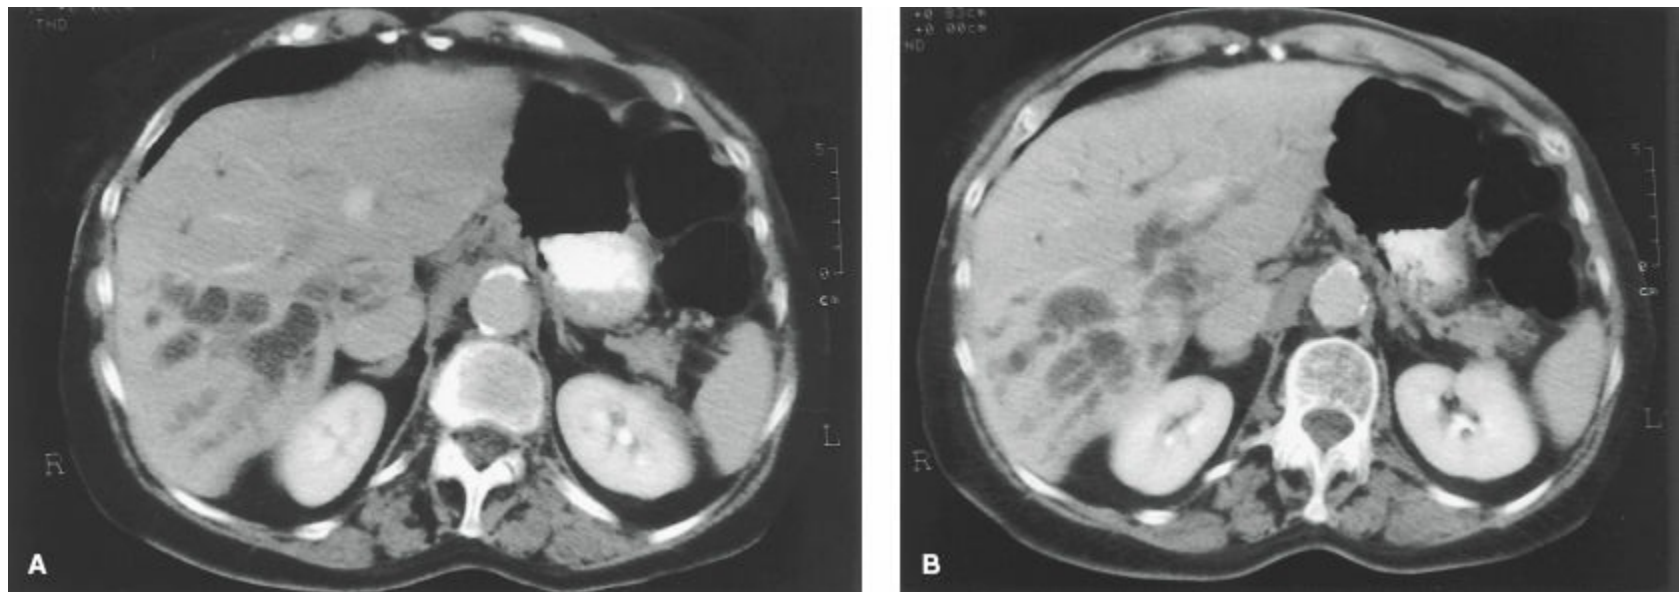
Computed tomography scan in a patient with hilar cholangiocarcinoma, demonstrating dilated intrahepatic ducts in the right lobe but inability to directly visualize tumor.
